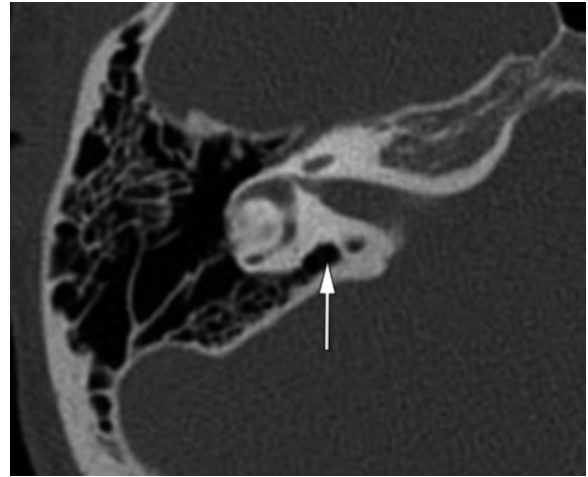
Pneumatization of the IAC. Axial nonenhanced CT scan (bone algorithm) shows hyperpneumatization of the posterior wall of the IAC (arrow), which increases the risk of postoperative CSF leak.
